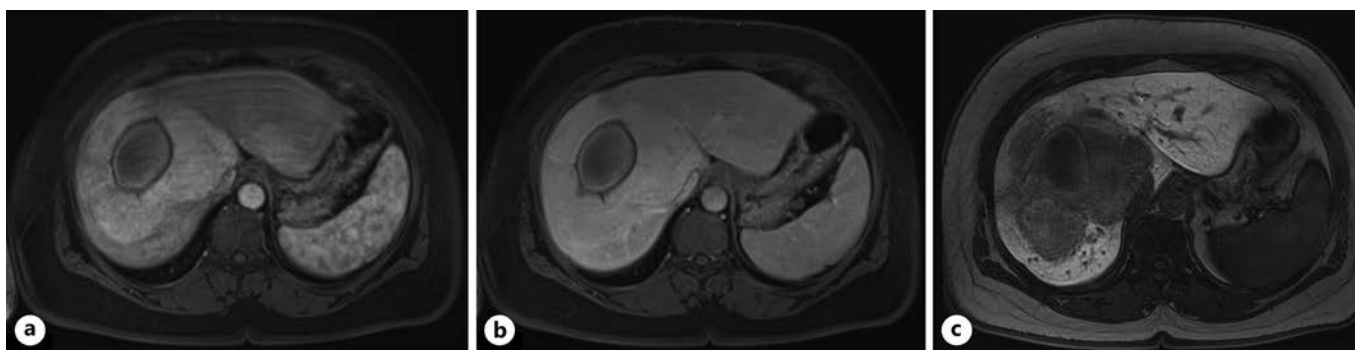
Abdominal MRI with hepatobiliary-specific contrast. Peripheral solid component showing enhancement on arterial phase (a), isointense (no washout) on portal phase (b), and hypointense on hepatobiliary phase (c) mass with $7.2 \times 6.1 \times 4.6$ cm in segments VII, VIII, and I with a central hematic area secondary to the previous bleeding, suggestive of an HCA, more likely inflammatory or hedgehog subtype.
